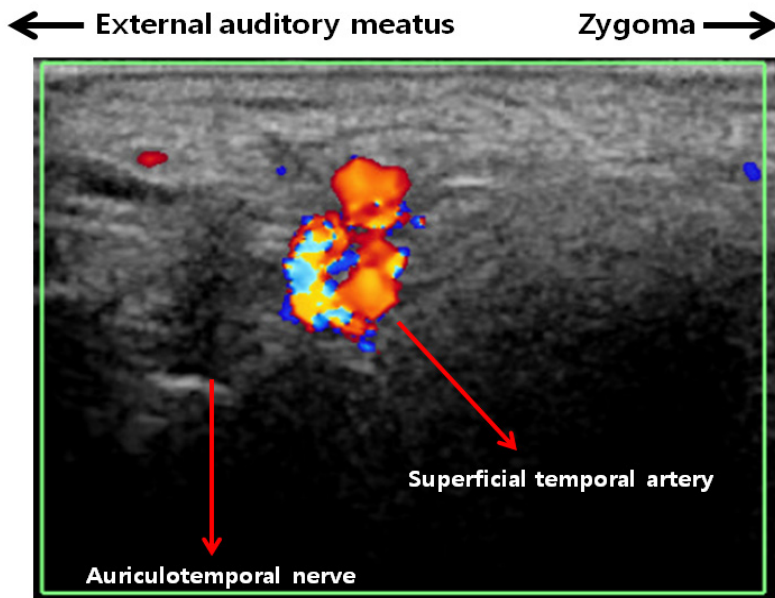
Ultrasound finding of superficial temporal artery and ATN.
